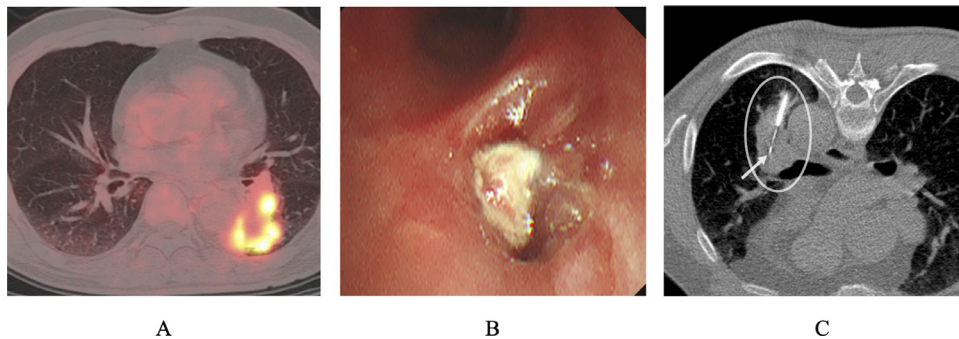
^{18}F -fluorodeoxyglucose positron emission tomography CT, bronchoscopy image and CT-guided lung biopsy. Thirty-five months later, ^{18}F -fluorodeoxyglucose positron emission tomography CT showed a high degree of accumulation (SUV_{max} , 8.7-9.2) at the left lung lesion (A), and areas of suspected cancerous invasion to the bronchial mucosa was observed by bronchoscopy (B). Finally, CT-guided lung biopsy for the left mass was performed (C). A 18 G semi-automatic needle (MISSION, BARD Medical, Covington, GA, USA) was used to perform 2 biopsies in a prone position through the left back intercostal approach. The arrow indicates the tip of the biopsy needle, indicating that the biopsy needle has penetrated the left lung mass (circle).
